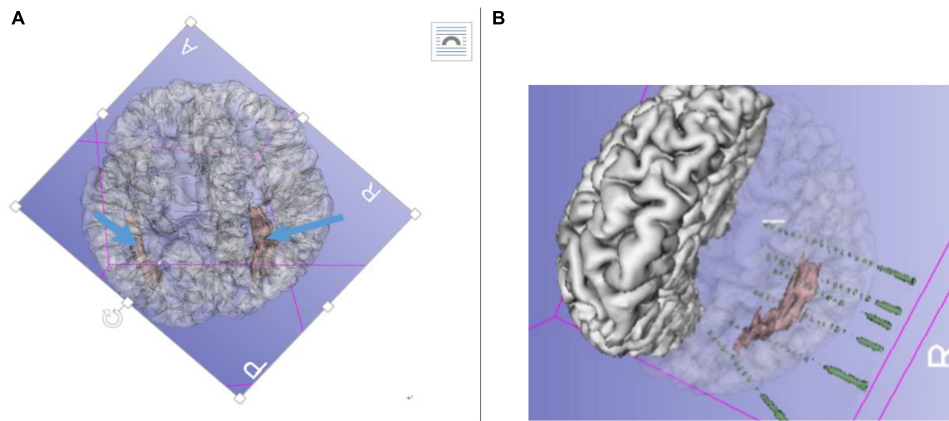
(A) Pre-radiofrequency thermocoagulation (RFTC) 3D reconstruction MRI showing bilateral gray matter nodular heterotopia (GMNH), arrow. (B) Reconstruction of electrodes superimposed on GMNH.
